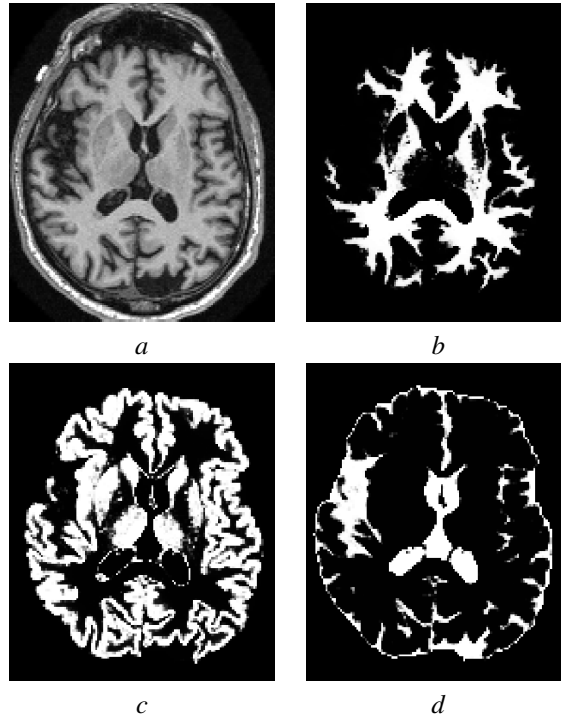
(a) T1-weighted MRI image of a human brain segmented in to its 3 main tissue classes (b) white matter, (c) grey matter and (d) cerebrospinal fluid.
